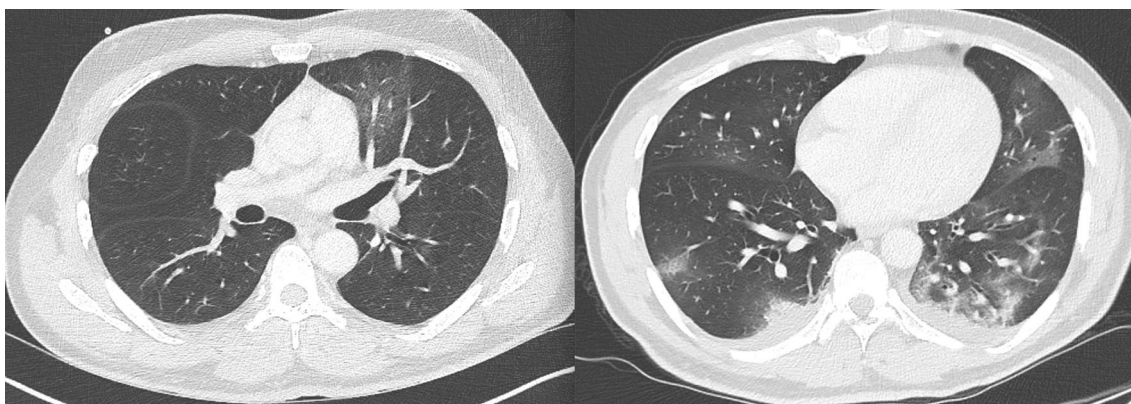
Chest CT-scan demonstrates ground glass opacities in the left lower pulmonary lobe (left) and repeat CT-scan (right) showing bilateral pulmonary lesions with crazy-paving pattern
